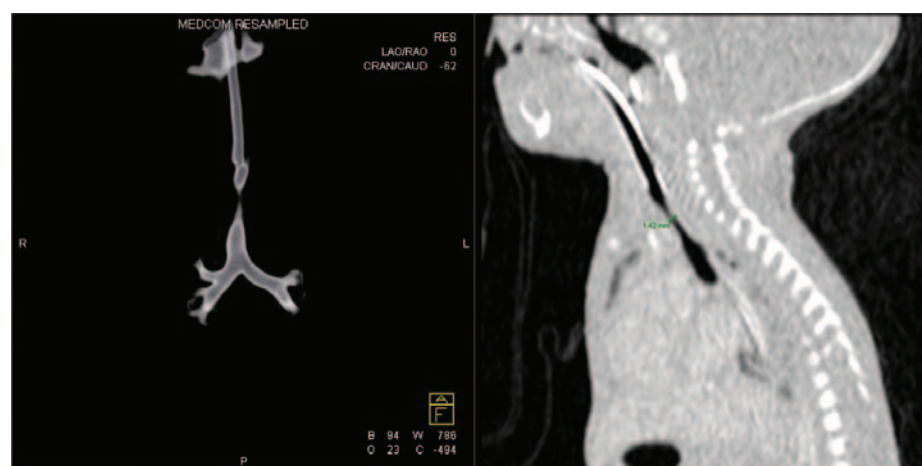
CT images showing congenital tracheal stenosis of 7-8mm and a normal distal trachea.
